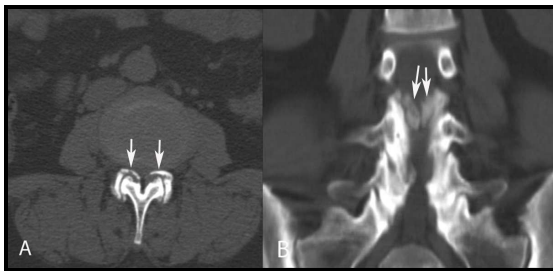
Axial (A) and coronal reformatted (B) bone window CT images demonstrating bilaterally V-shaped hyperdensity consistent with ossification of the ligamentum flavum (arrows).
